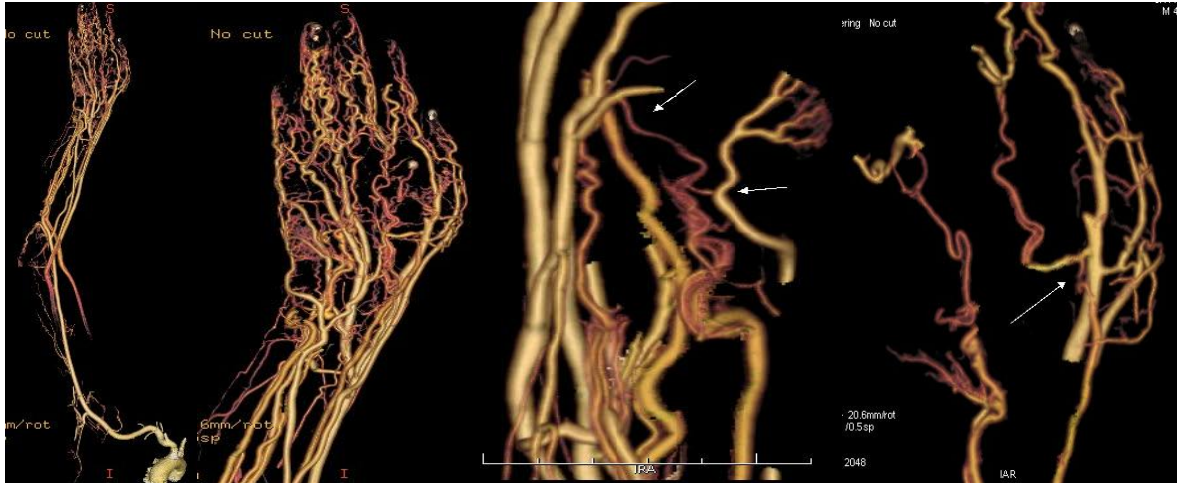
(A-D) CTA 3D volume rendered multiplanar images reveal multiple arterio-venous fistula of right hand.
